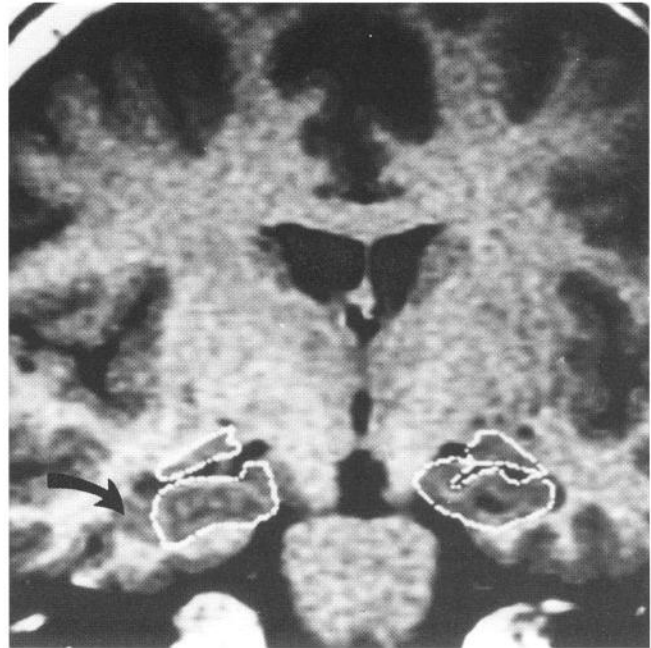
Coronal MRI scan showing a moderate-sized area of heterotopic gray matter (arrow) adjacent to the head of the right hippocampus. The patient had complex partial seizures originating from the right temporal lobe. The two hippocampi (lower outlines) and amygdalae (upper outlines) are outlined and do not show atrophy of the right side.
